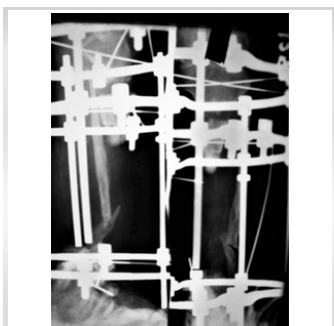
X-ray 10 days after corticotomy.
